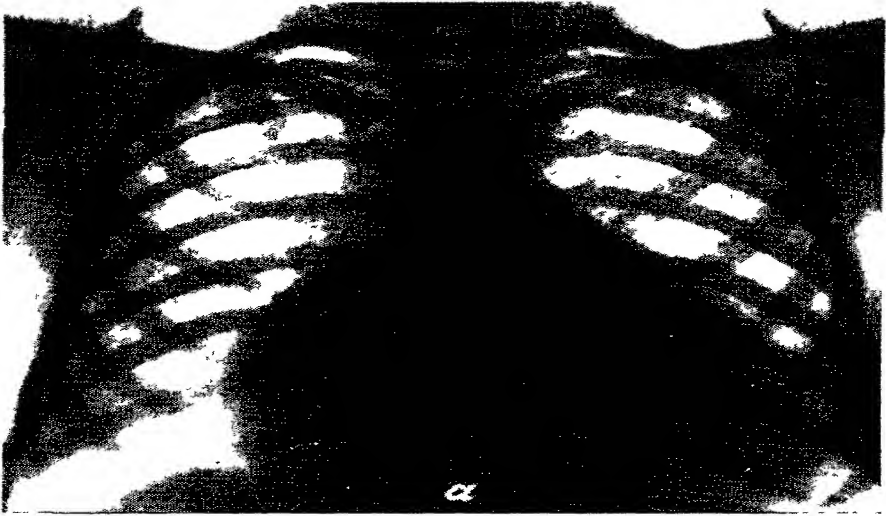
X-rays of patient T Acute miliary tuberculosis, tuberculous meningitis and pericarditis before treatment
